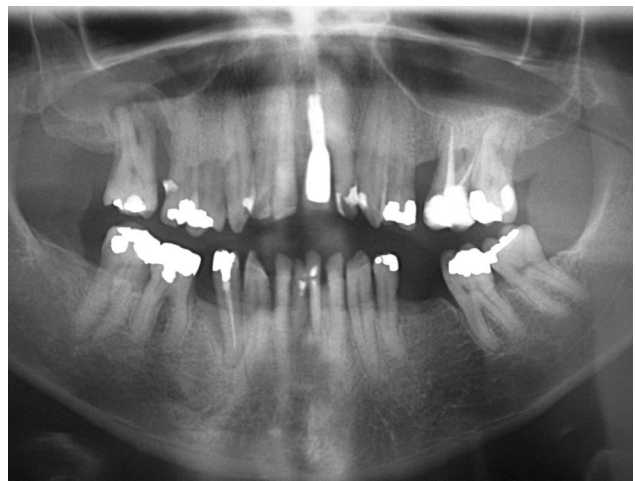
Panoramic radiograph showed dental losses and generalized bone loss in alveolar ridges
